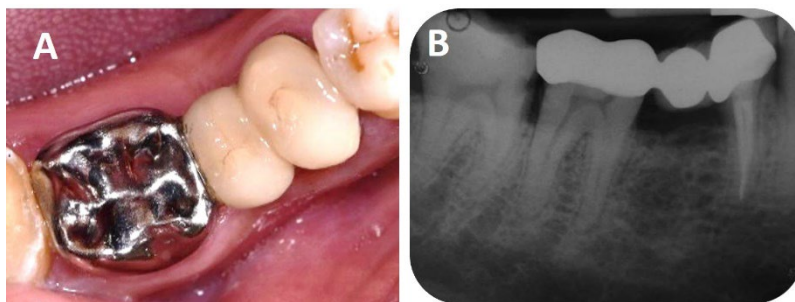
Bridge insertion and 1-year follow-up for tooth 46. A: Occlusal view of fixed-fixed bridge with full metal on abutment tooth 47 and porcelain-fused metal on hemisected tooth prepared as two premolars. B: 1 year review radiograph, showing no evidence of periapical radiolucency on both 46 and 47. The margins of the bridge appeared intact.
